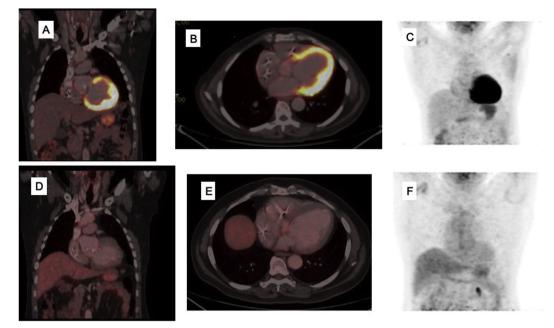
A, B, C- Significant myocardial and lymph node uptake at presentation. D, E, F- Complete resolution of FDG uptake after 1 year.
